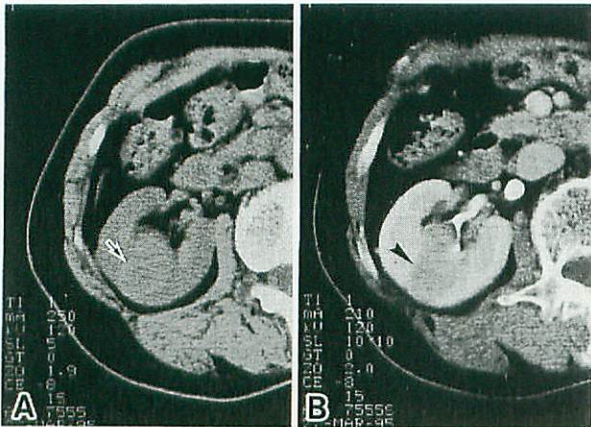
A and B: CT scans before (A) and after (B) the injection of contrast material, showing an essentially iso-density mass (arrow) (CT attenuation number: 30 Hu) with homogeneous enhancement (arrowhead) (CT attenuation number: 50 Hu).
